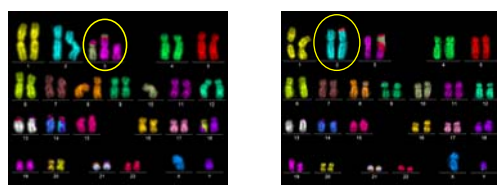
mFISH analysis of clonal translocations (circles) in AG1522 cells, occurring at different passage numbers after exposure in control cells (left) as well as in the progeny of irradiated cells (right, here shown for 8 x 2 Gy X-rays).
